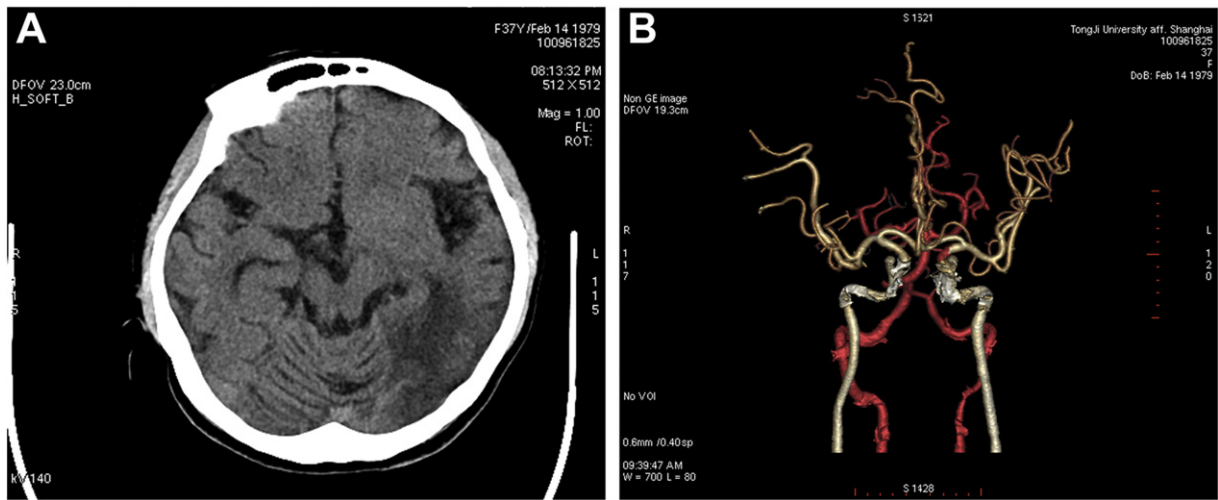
CT scan showed lesions of hypodense in the left temporal and parietal lobe (Panel A). Three-dimensional reconstruction of CT vessel images (Panel B).
